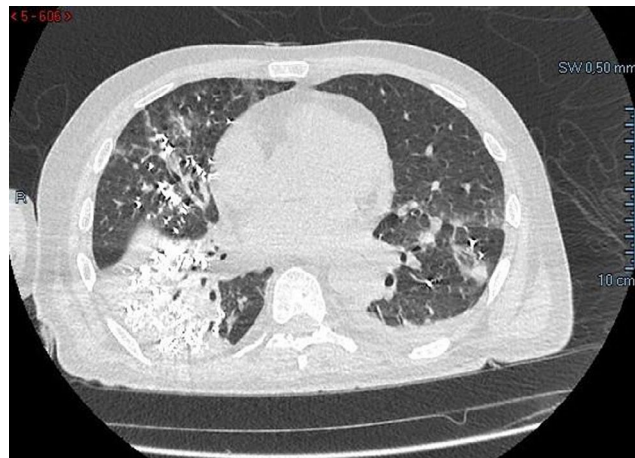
CT chest image showing presence of barium at the pulmonary bases with thickening of the basal parenchyma of the right lung
